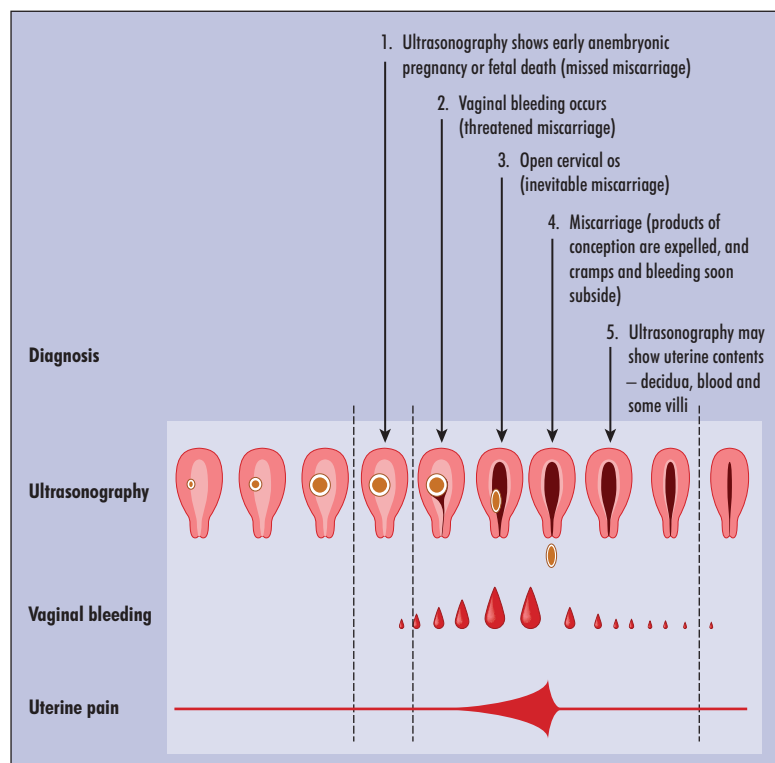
Natural course of miscarriage with clinical and sonographic findings. From Ankum et al (2001).
